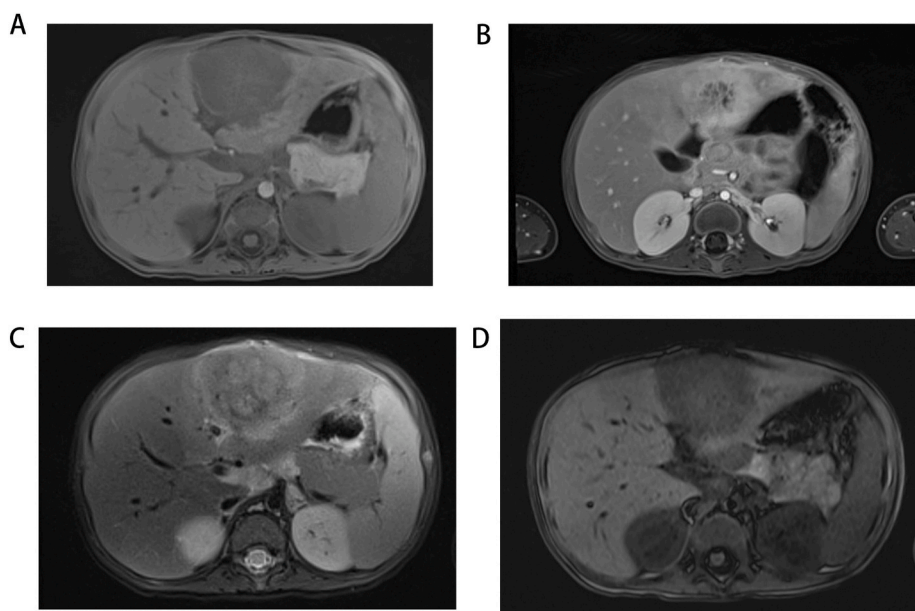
Abdominal MRI: There is a mass shadow with mixed signal in the SIV segment of liver. (A) Shows that the lesion had a certain mass effect, the adjacent liver parenchyma was compressed, and the edge of the lesion was blurred. In (B), the enhanced scan showed that the lesions had honeycomb-like enhancement, and there were narrow-band edema signals with no enhancement around the lesion; the lesion size was 55mm × 42mm × 64mm (left and right × front and rear × up and down). (C) Shows that the left portal vein and its branches surrounded the lesion and became thinner under pressure. The left hepatic vein ran through the lesion without clear narrowing. (D) Shows that the lesion protruded backward and compressed the head of pancreas, and the splenic vein behind the pancreas head became thinner.
